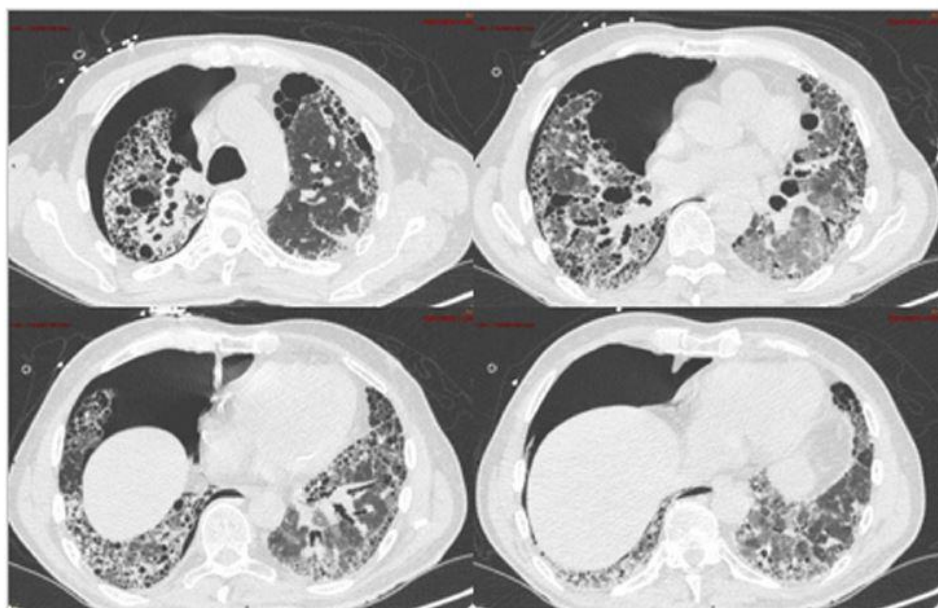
Parenchymal window of the chest CT scan in a patient with an acute exacerbation of idiopathic pulmonary fibrosis and complete right pneumothorax. Presence of diffuse ground-glass opacities, associated with reticulations and traction bronchiectasis.
